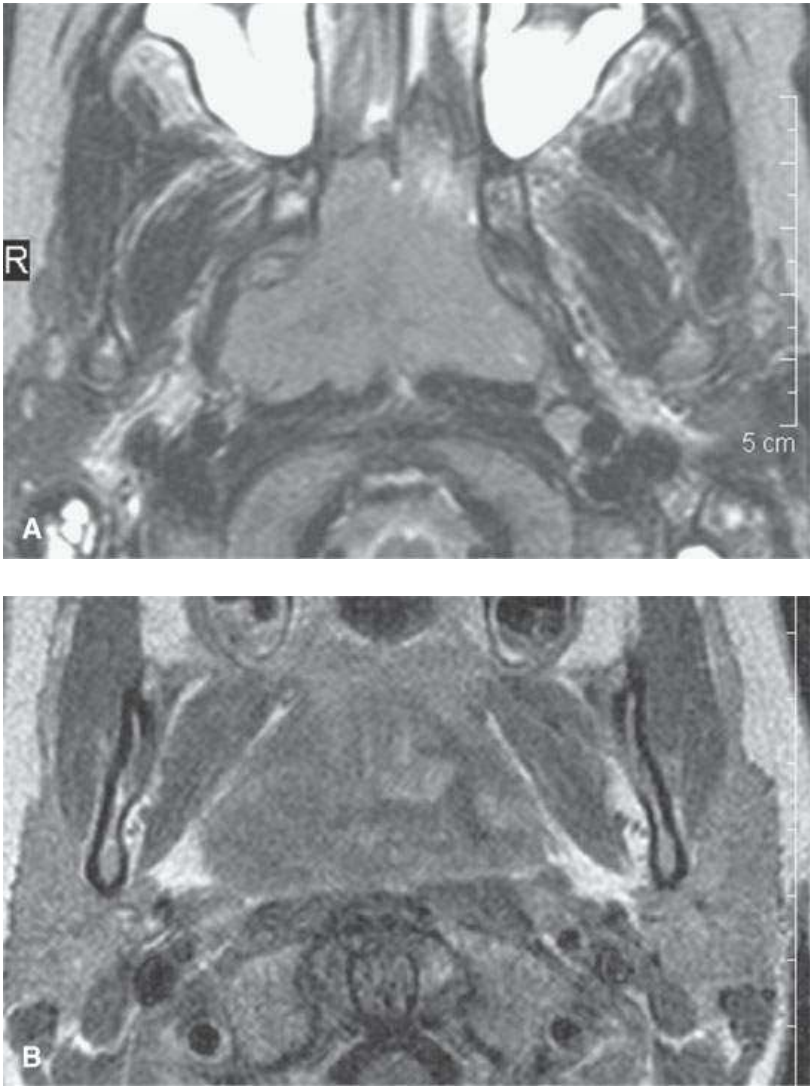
Magnetic resonance imaging of a patient with Burkitt lymphoma showing that on the T2-weighted image in (aA), the tumor is about the same signal intensity and normal lymphoid tissue but on the T1-weighted contrast-enhanced image (B) shows an inhomogeneous pattern different from that usually seen in normal lymphoid tissue.
